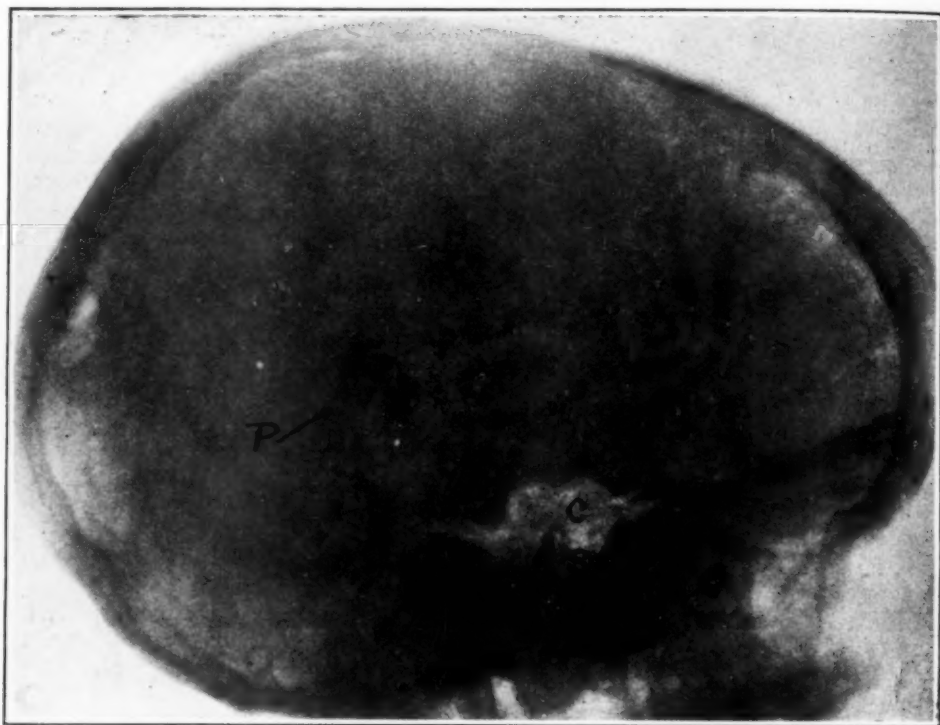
X-ray photograph of Case 1. P probable pineal shadow which is exceedingly large. C large cisterna chiasmatis filled with air. (The shadows have been intensified.) S sella turcica, slightly larger than normal. Air-filled sulci are seen over the frontal region.
